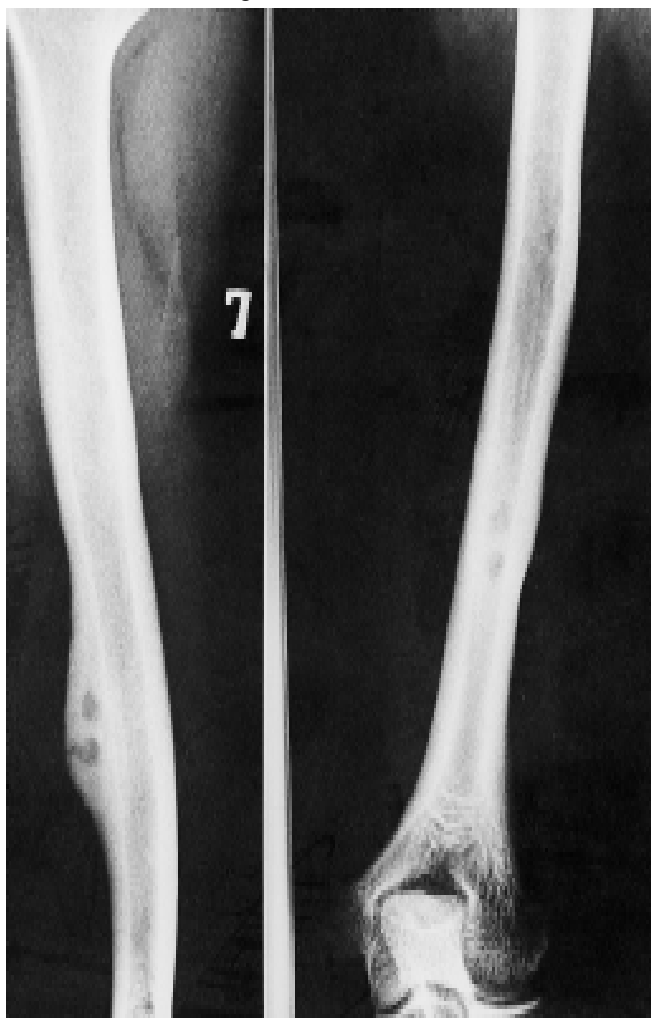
Radiograph humerus showing two lucent lesions.
